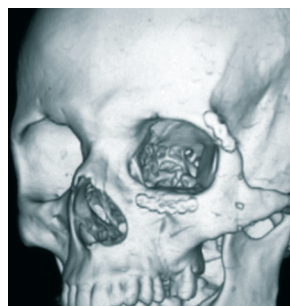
Posop. CT. Coronal and 3D views.
